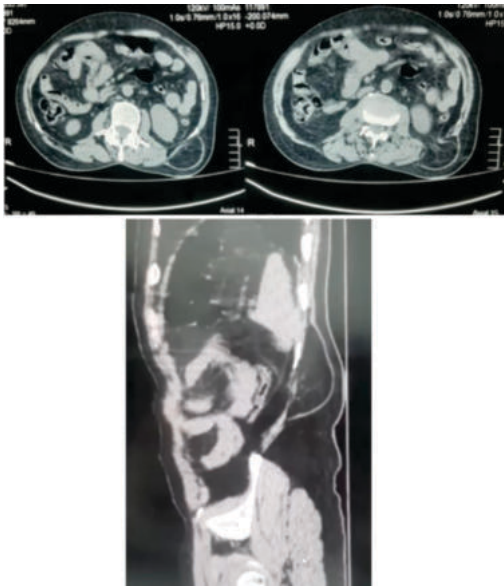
CT images showing the defect in the left lumbar region (Axial and sagittal sections).
